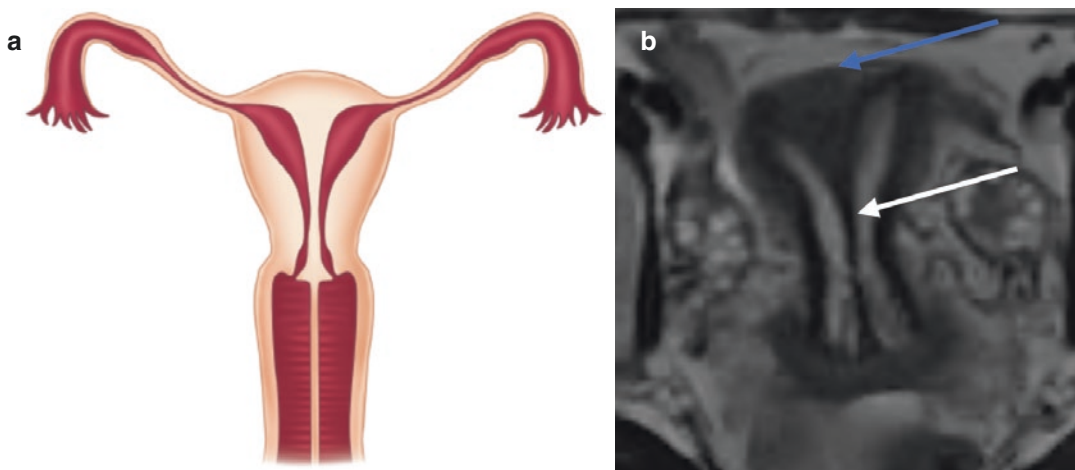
Complete uterine septum. (a) Depiction of complete uterine septum. (b) MRI of complete uterine septum (Blue arrow: Normal fundal uterine contour) (White arrow: Complete uterine septum)
